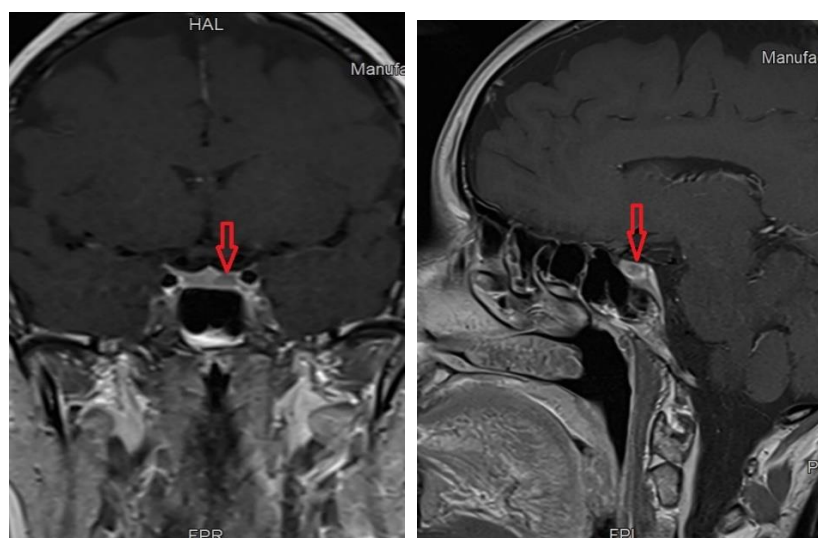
Contrast-enhanced Brain MRI with red arrow indicating the location of pituitary gland lesion.
